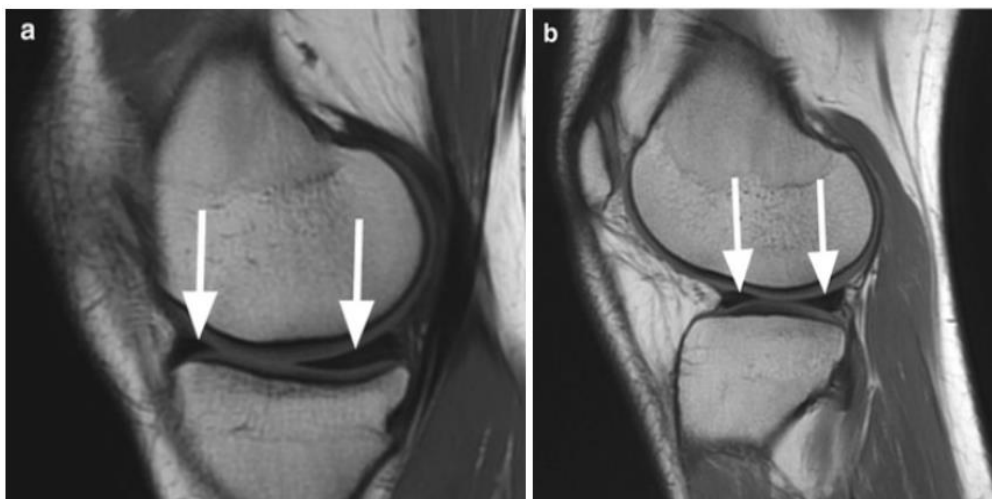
Sagittal MRI images of normal menisci (a) Image through the medial compartment showing medial meniscus which is wider posteriorly than anteriorly (*arrows*) (b) Image through the lateral compartment shows the normal homogeneous hypointense anterior and posterior horn of the lateral meniscus (*arrows*).
